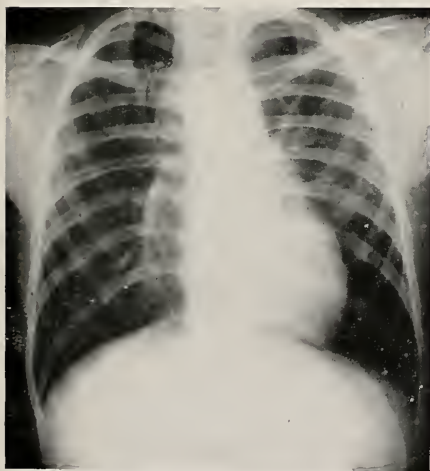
Case III—X-Ray: Patent Ductus Arteriosus
